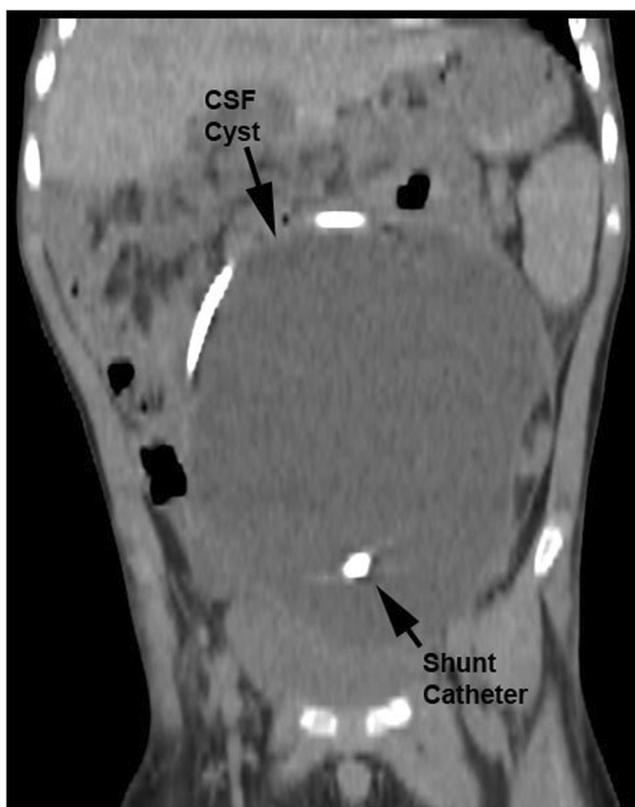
Abdominal CT scan of the patient shows an intraabdominal cyst. (CSF, cerebrospinal fluid)
